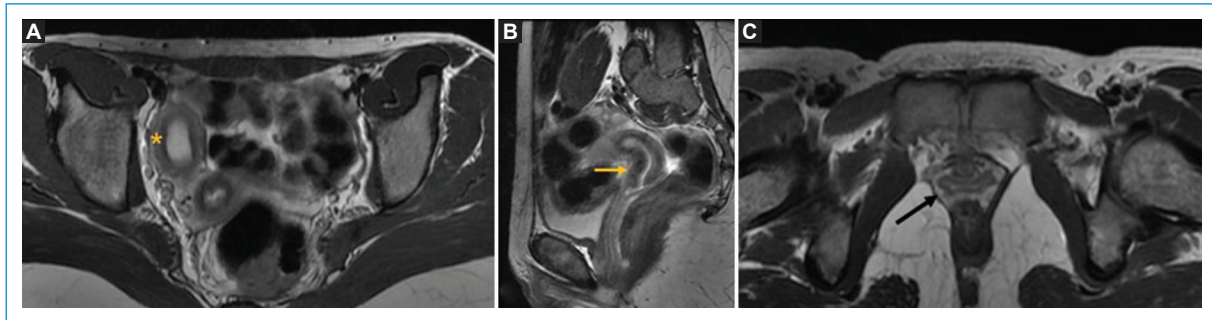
Uterine malformation. Axial T2-weighted image of the pelvis (A) shows a right deviated, unicornuate uterus (yellow star), without a rudimentary horn. Sagittal T2-weighted image of the pelvis (B) reveals an unilateral cervix (yellow arrow). Axial T2-weighted image of the pelvis at a lower level (C), depicts a normal vagina (black arrow).
